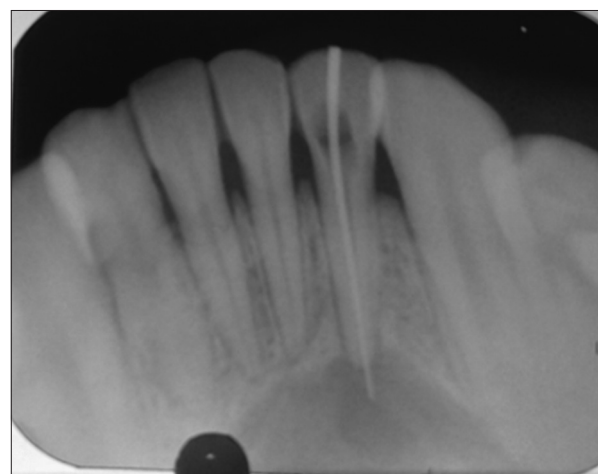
Diagnostic radiograph
